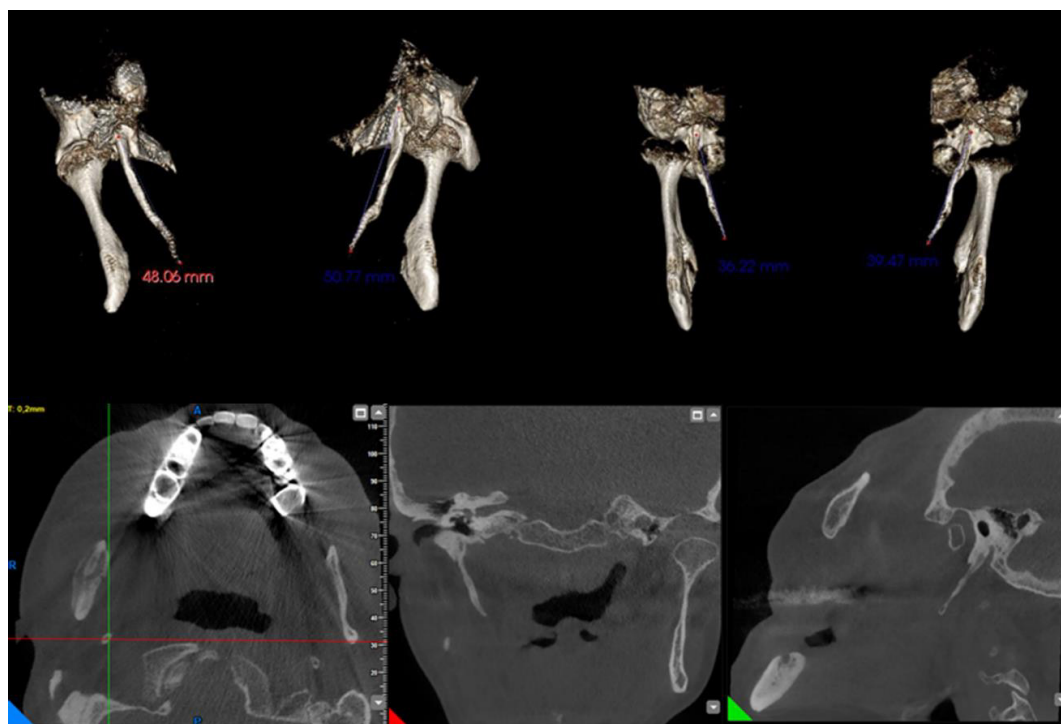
Coronal, Axial and Sagittal views of CBCT Image.
